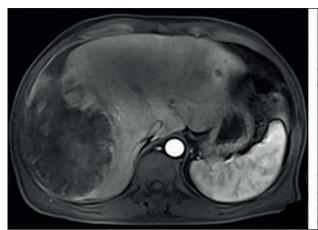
MRI of liver cancer with low expression of Beclin1. Mixed edge and internal enhancement were observed.
